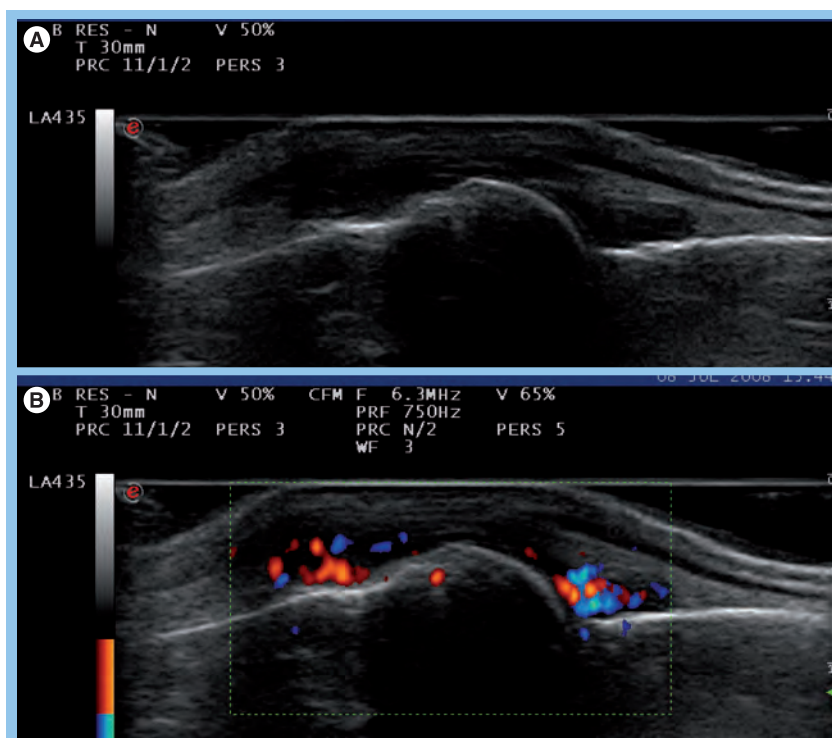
Dorsal longitudinal view of a metacarpophalangeal joint. (A) Grayscale and (B) Doppler sonographic image of arthritis of a metacarpophalangeal joint of a patient with active rheumatoid arthritis.
